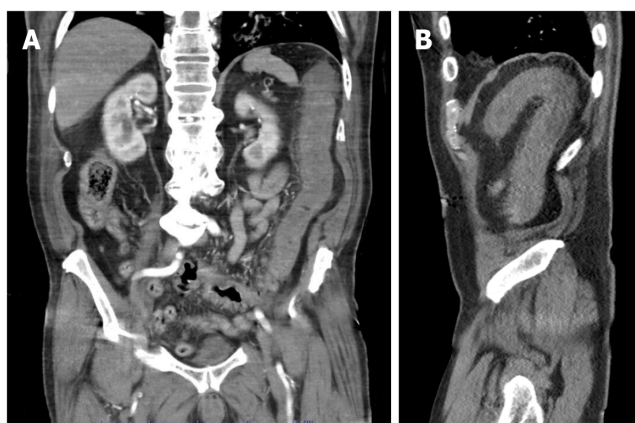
Acute ischemic colitis. A and B: Coronal (A) and sagittal (B) reconstructed images from a computed tomography angiogram of the abdomen and pelvis in an 80-yr-old male admitted for sepsis and lactic acidosis. There is bowel wall thickening and hypoenhancement involving the descending colon, with surrounding inflammatory changes. There is no evidence of pneumatosis coli, pneumoperitoneum or proximal vessel occlusion. Bilateral ground-glass opacities were visualized at the lung bases (not shown). The patient was positive for severe acute respiratory syndrome coronavirus 2.
